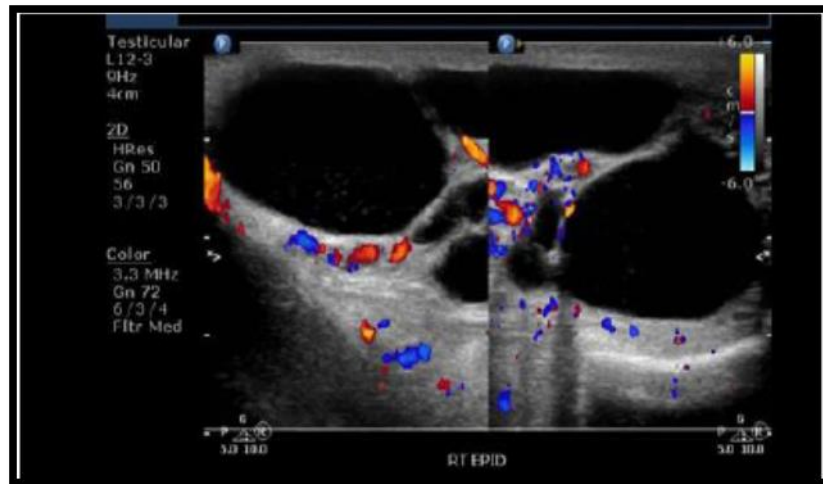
Shown above are 2D B-mode and color Doppler ultrasound images of multiple right Epididymal cysts in the head of the right epididymis. Surprisingly the septae show remarkable vascularity (Choyke et al, 1997).
